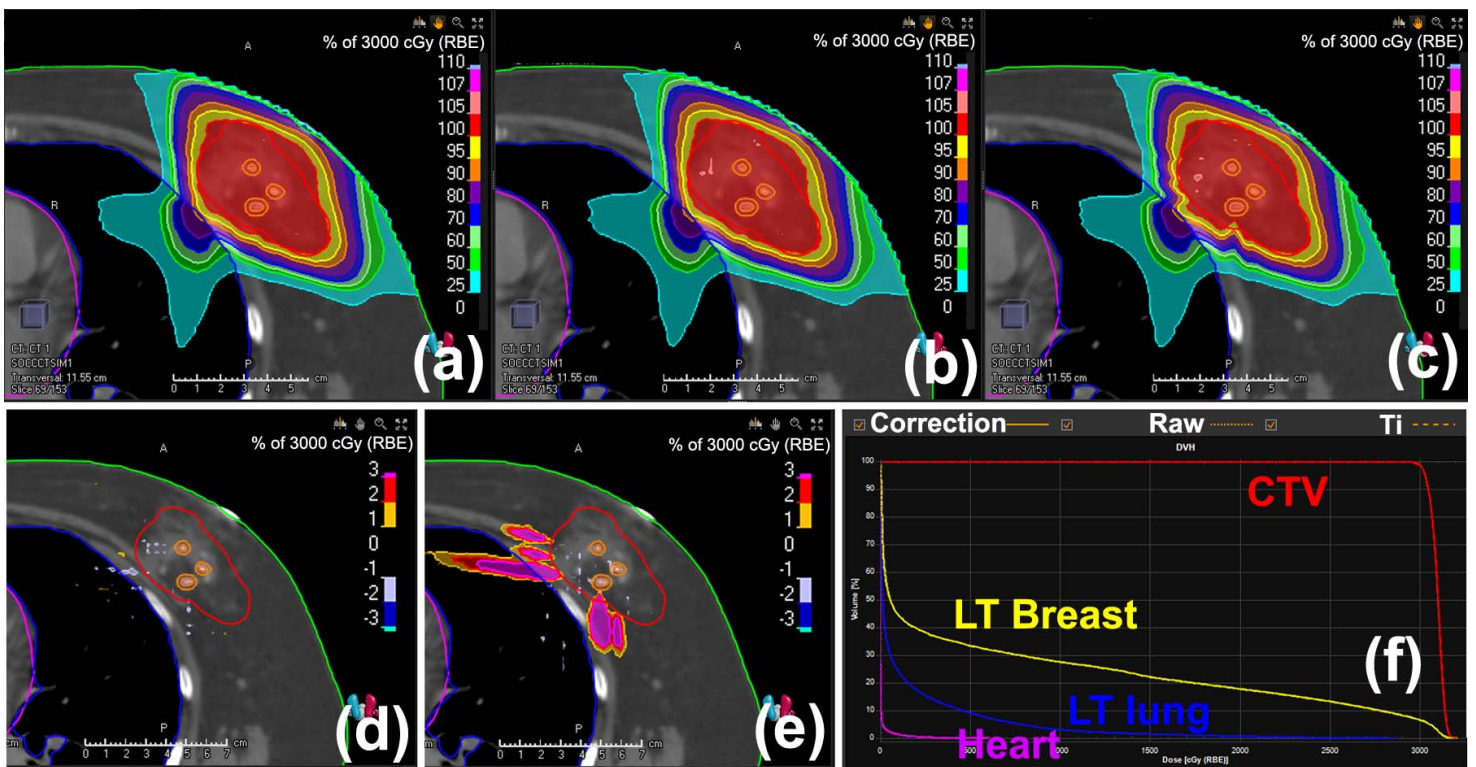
Comparison of APBI plans for patient 1: (a) original plan with density correction; (b) recalculation with the raw CT; (c) recalculation with Ti density for clips; (d) dose difference between (a) and (b); (e) dose difference between (a) and (c); and (f) DVH comparison (solid line: density correction; dotted line: raw CT; dashed line: Ti density—almost identical for all structures). Abbreviations: APBI, accelerated partial breast irradiation; CT, computed tomography; CTV, clinical target volume; DVH, dose volume histogram; LT, left; Ti, titanium.
